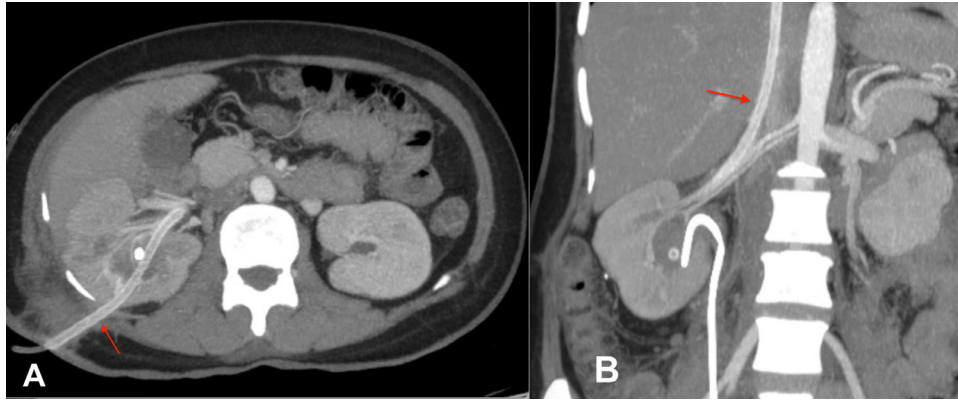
Maximum intensity projection CT scan images reformation on axial (A) and coronal (B) views showed the nephrostomy catheter (arrow) transverse the renal calyx then situated in the inferior vena cava.
